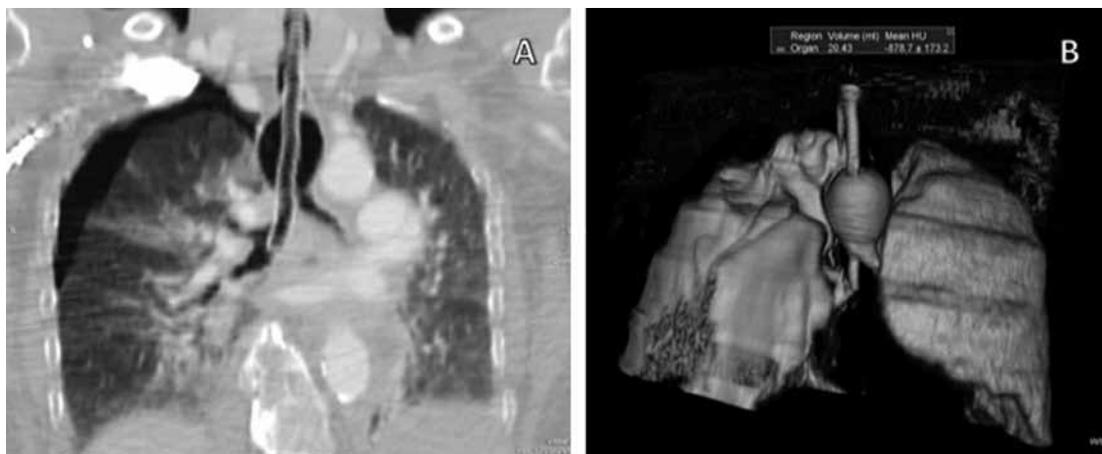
Computed tomographic scans of thorax. A) Coronal view; B) 3D view.
